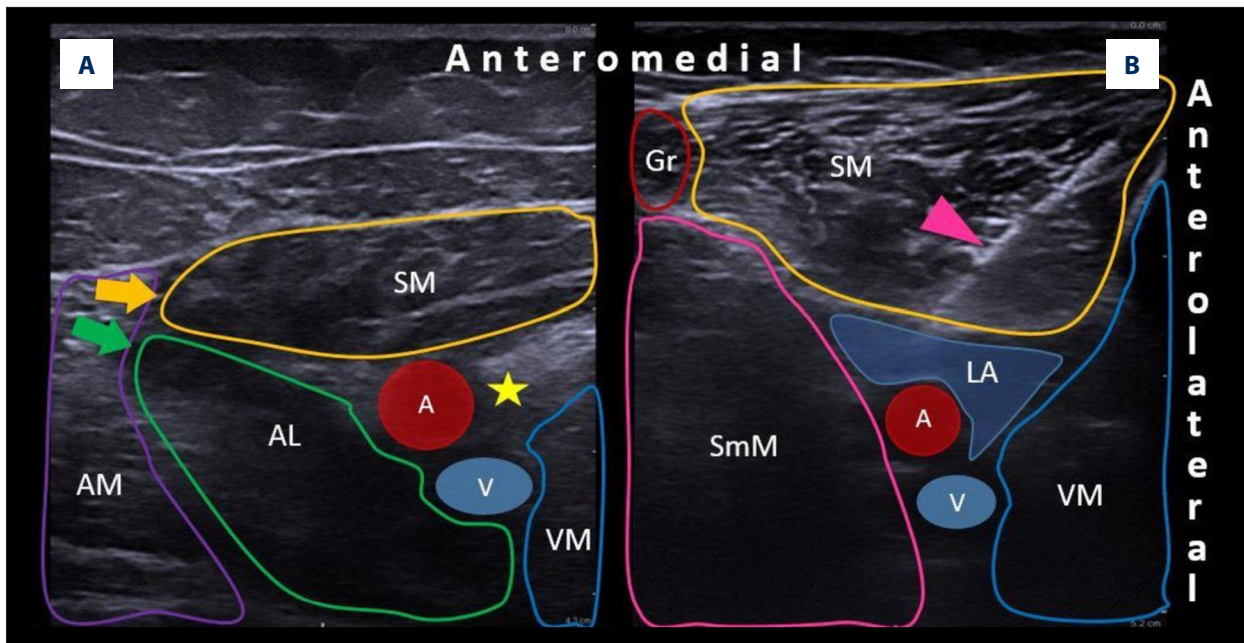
The ultrasonographic views: the apex of the femoral triangle (A) and the distal end of the adductor canal (B). The apex of the femoral triangle (A) was found at the level where the medial border of the sartorius muscle (yellow arrow) intersects the medial border of the adductor longus muscle (green arrow). Local anesthetic was injected laterally to the femoral artery (yellow star) where the saphenous nerve is located. The distal end of the adductor canal (B) was found at the level where the femoral artery and vein dive deeper from the sartorius muscle and become the popliteal vessels. The needle (pink arrowhead) was placed and the local anesthetic was injected above the artery. SM – sartorius muscle; AL – adductor longus muscle; VM – vastus medialis muscle; AM – adductor magnus muscle; Gr – gracilis muscle; SmM – semimembranosus muscle; A – femoral artery; V – femoral vein; LA – spread of local anesthetic after injection.
